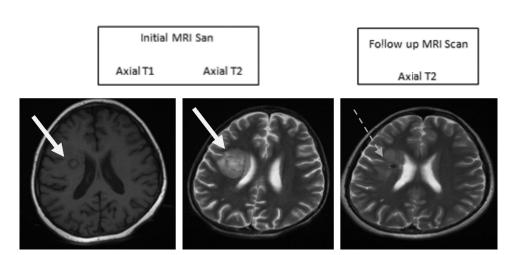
A) Initial MRI showing lesion (white solid arrow) in right lobe adjacent to the body of right lateral ventricle that is hypointense in T1 and hypertense with surrounding white matter vasogenic edema in T2. B) Follow up MRI showing reduction in size of the lesion and perilesional edema in T2 (white dotted arrow)
